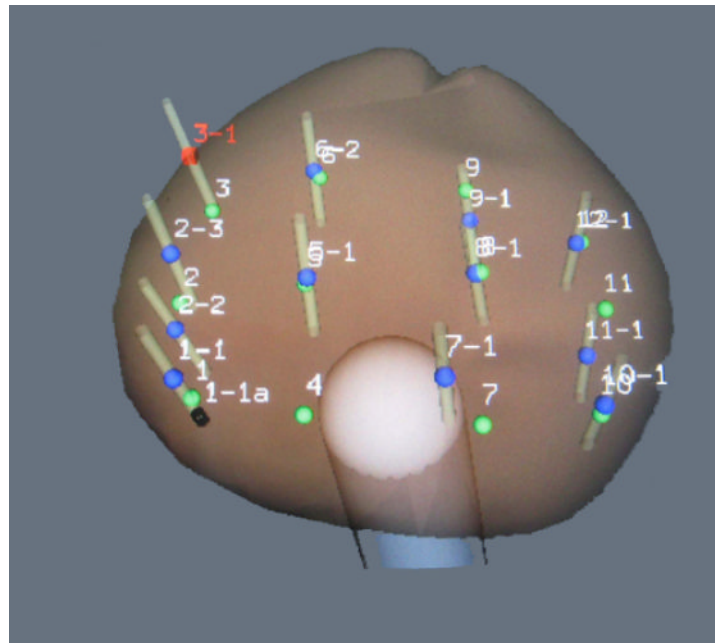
Targeted biopsy using MR Fusion. (a) A lesion was identified on MRI (Image grade 4) and delineated on T2WI by radiologist, blue ellipse. The axial T2WI and area of interest was fused with real-time ultrasound images. (b) Lesion was identified in sagittal and axial planes (blue enclosures), and biopsy-targeting of the lesion was established (parallel lines overlying blue enclosures). Both targeted and systematic biopsies were performed under real-time ultrasound guidance. (c) Sites of systematic and targeted biopsies were recorded within 3D reconstruction of prostate, confirming that several targeted biopsies penetrated region of interest. Biopsy results showed a Gleason Score 3+3=6 cancer in only the targeted area.
